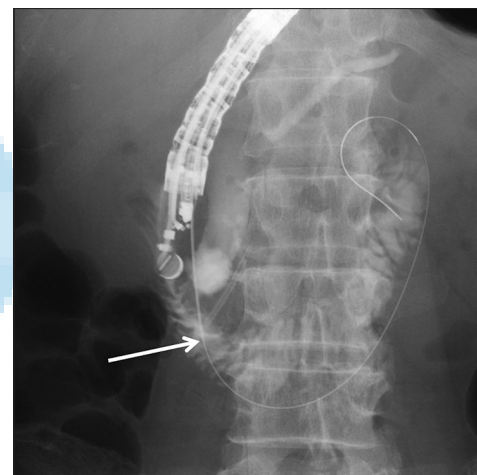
X-ray image showing that the needle is passing through the papilla. The needle tip (arrow) was located inside the duodenal lumen
